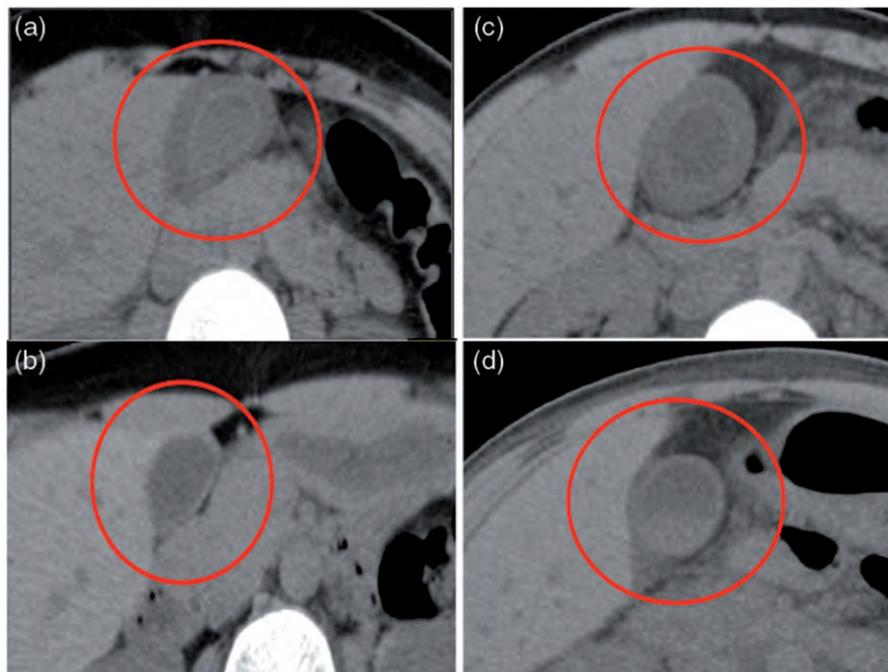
Abdominal computed tomography showing gallbladder. (a,c) edematous gallbladder without gallstones, (b,d) improvement of bladder wall thickness.
